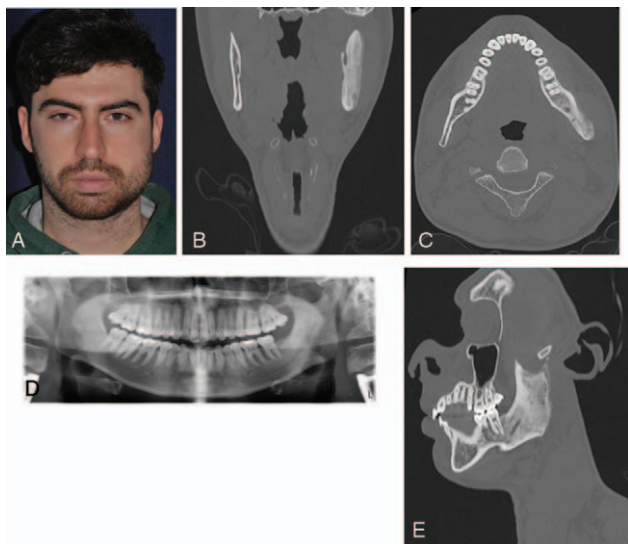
(A) Preoperative clinical image with evident swelling of the left mandible. (B) OPG at onset of disease shows a diffuse osteolytic and osteosclerotic process of the left mandible ramus, excluding the condyle. (C) Computed tomography scan coronal corresponding to the orthopantomograph shown in A; it shows a mixed pattern with sclerotic and lytic zones of the left mandibular ramus, a subperiosteal bone formation with thickening of the left mandibular angle and the dissolution of the cortical boarder. (D). Computed tomography scan axial corresponding to the orthopantomograph shown in A; it shows a mixed pattern with sclerotic and lytic zones of the mandibular ramus, a subperiosteal bone formation with thickening of the left mandibular angle and the dissolution of the cortical boarder. (E) Computed tomography scan axial corresponding to the orthopantomograph shown in A; it shows a mixed pattern with sclerotic and lytic zones, a subperiosteal bone formation with thickening of the left mandibular angle and the dissolution of the cortical boarder. (F) Computed tomography scan sagittal corresponding to the orthopantomograph shown in A; it shows a mixed pattern with sclerotic and lytic zones, a subperiosteal bone formation with thickening of the left mandibular ramus and the dissolution of the cortical boarder.
